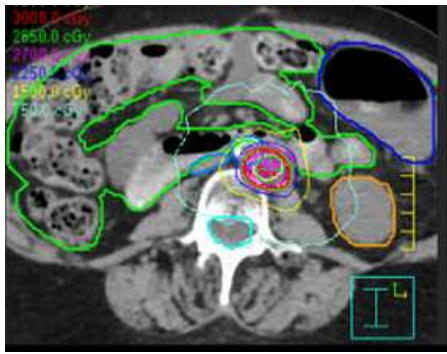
Transverse CT scan image in patient with ovarian cancer
